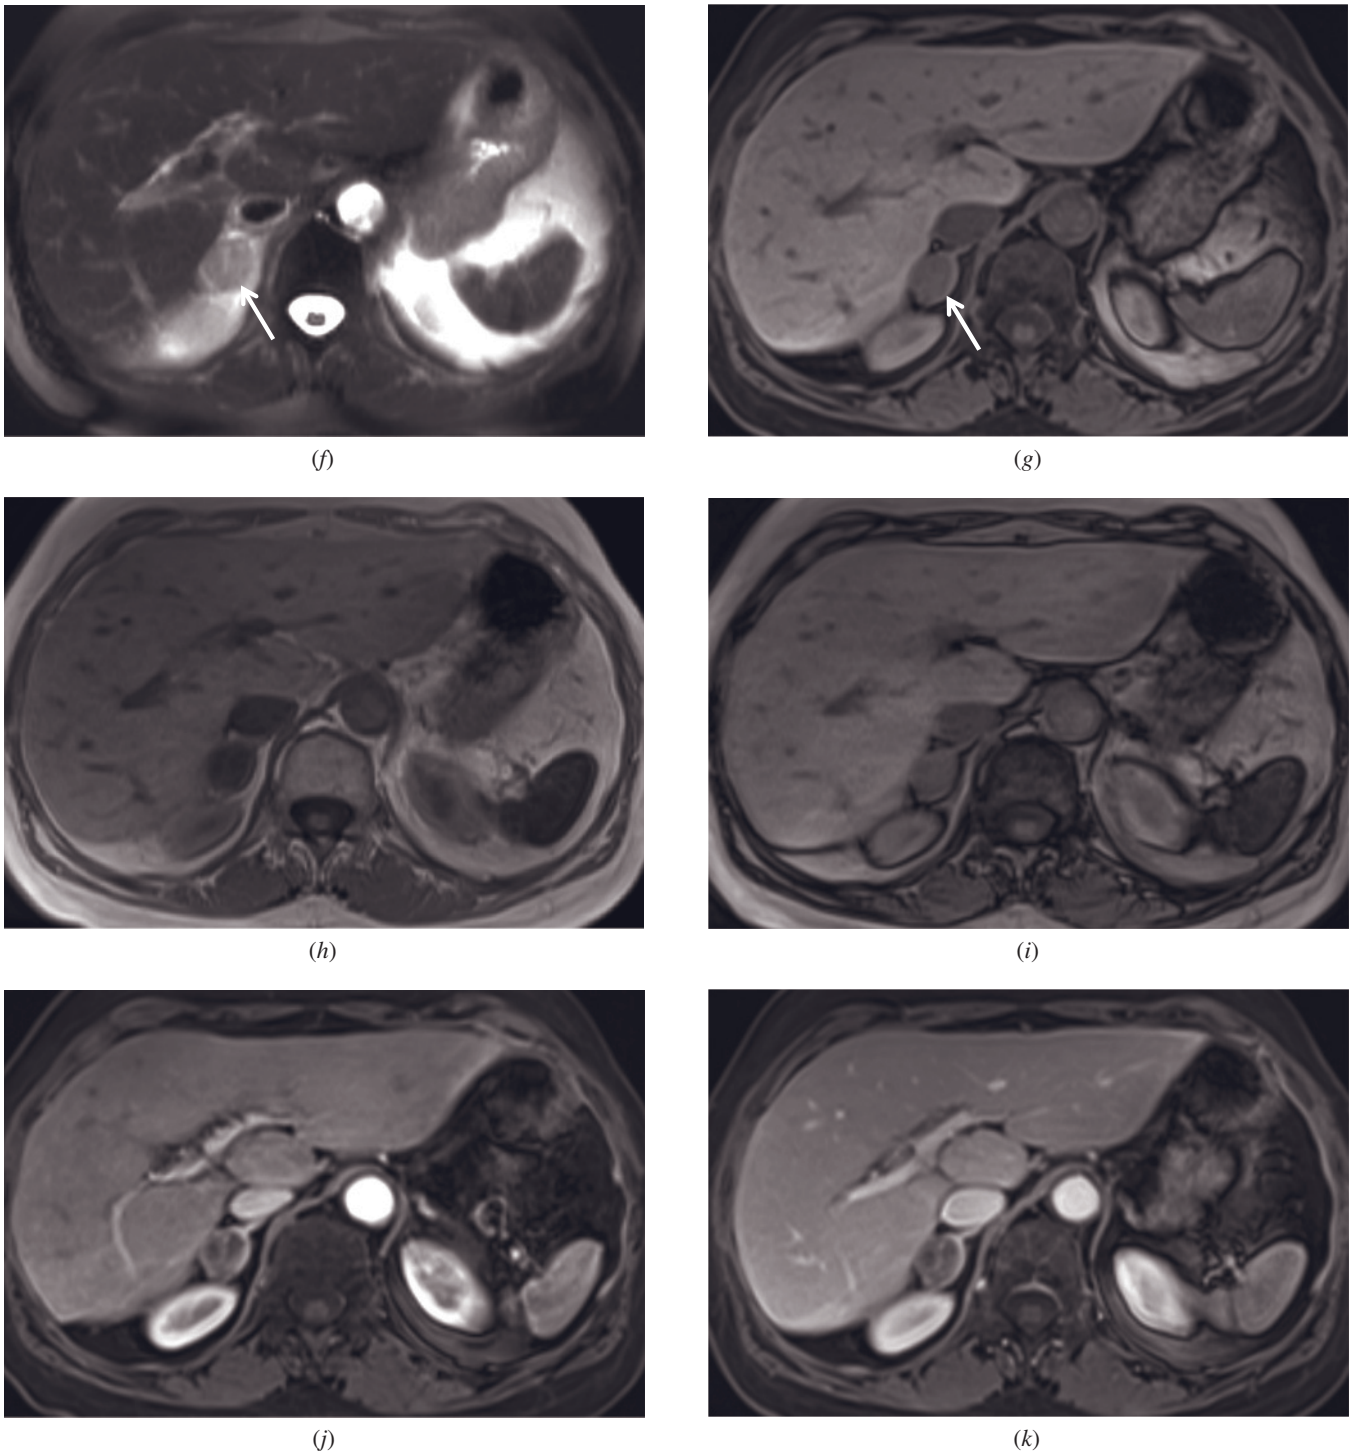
(Continued) fat-suppressed single-shot echo-train spin-echo (*f*), T1-weighted fat-suppressed 3D-GE (*g*), T1-weighted in-phase (*h*) and out-of-phase (*i*) 3D-GE, and T1-weighted postgadolinium hepatic arterial dominant phase (*j*) and hepatic venous phase (*k*) fat-suppressed 3D-GE images demonstrate a right adrenal gland metastasis (arrows, *f*, *g*) in another patient. The lesion shows high signal on T2-weighted image (*f*) and low signal on T1-weighted images (*g*, *h*). The lesion does not show any signal drop on out-of-phase image (*i*) compared to in-phase image (*h*). Heterogeneous enhancement is detected in the lesion on postgadolinium images (*j*, *k*).
